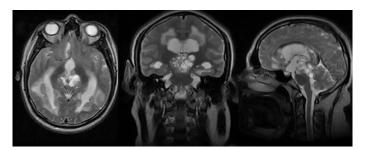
Brain magnetic resonance imaging, axial coronal and sagittal section in T1 sequence with gadolinium.
